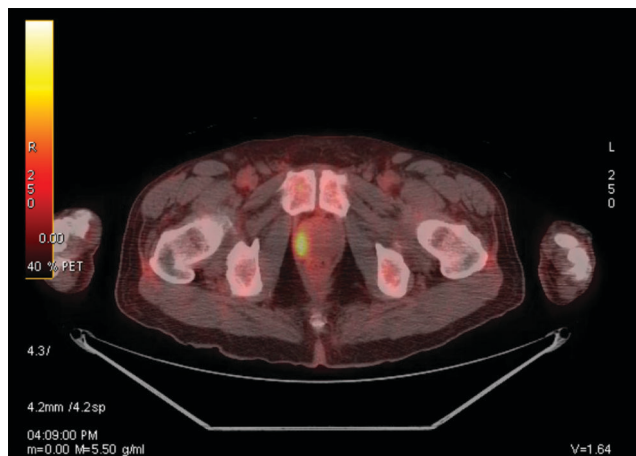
New focal uptake along the right lateral aspect of the prostate gland observed on PET-CT. The prostate may serve as a reservoir for cryptococcal infection (6).
